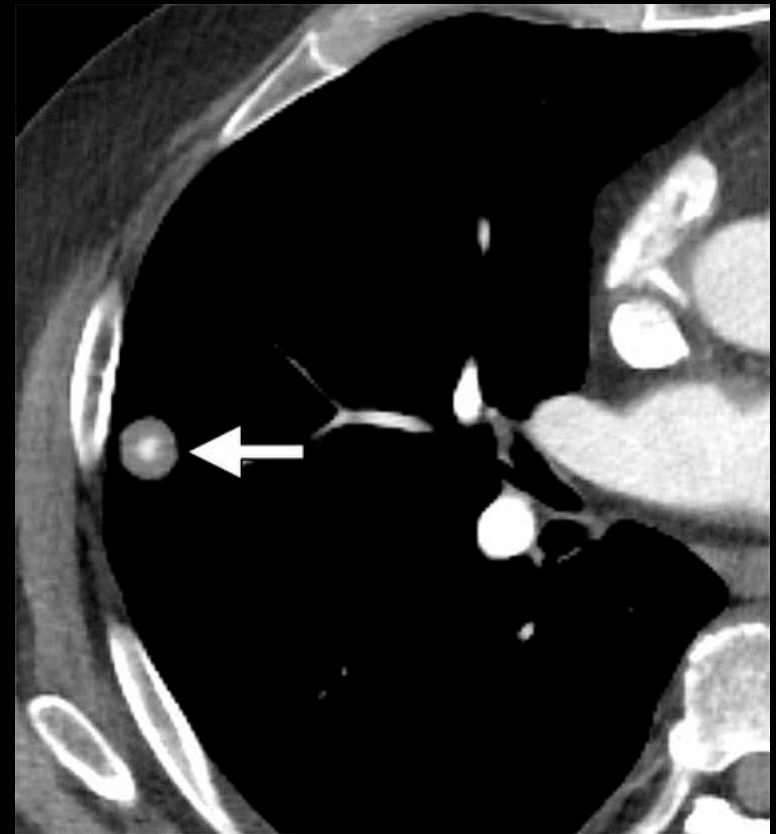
Solitary pulmonary nodule on CT scan*
